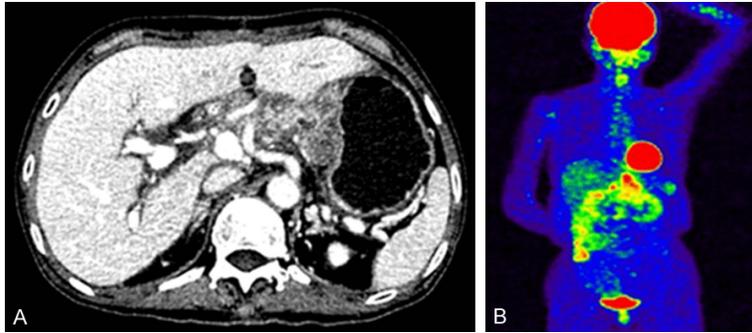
(A, B): Postoperative PET/CT showing no sign of intrahepatic or extrahepatic recurrence or metastasis at one year after transplantation.
